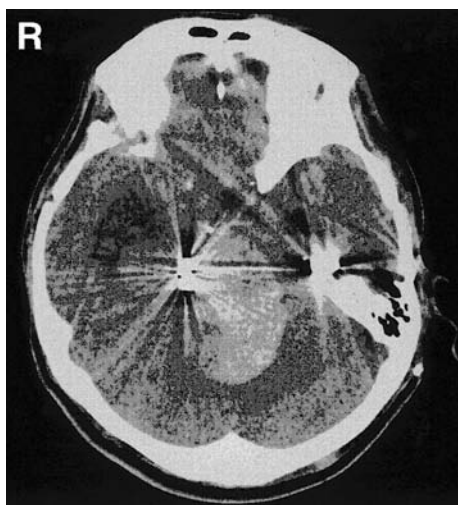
Computed tomography scan showing massive hemorrhage concentrating around the aneurysm.
